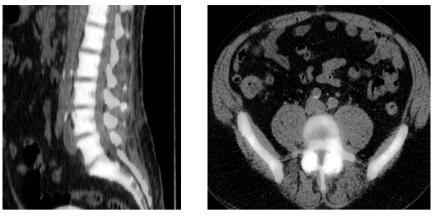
62-years-old male presenting with 2 years history of severe low back pain. The CT and MRI failed to show exact cause or level of pathology. The Fusion ¹⁸F-PET/CT images show bilateral intense uptake in both facet joints at L4-L5 level. The pathological uptake is more on the left side.
